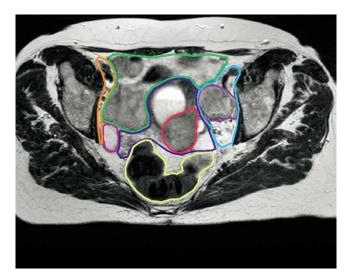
Delineation of the regions of interest on a T2-weighted magnetic resonance image: Bladder, pink; bowel, green; rectum, yellow; primary gross tumor volume, red; primary clinical target volume, blue; left nodal gross tumor volume, purple; left nodal clinical target volume, orange.
